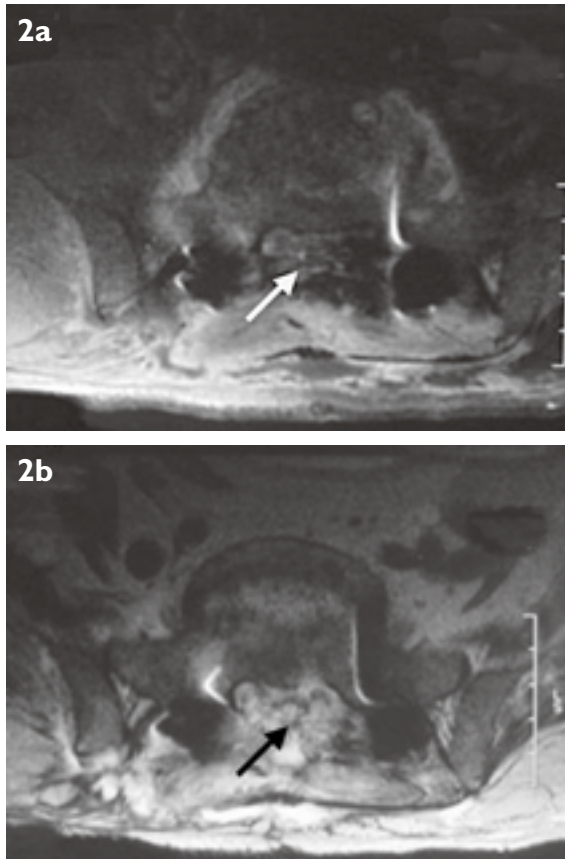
Axial MR images show severe constriction (arrow) of the lumbar sac by a posterior mass. The mass shows (a) mixed high and low signal intensity on T1-W and (b) high signal intensity on T2-W images.
